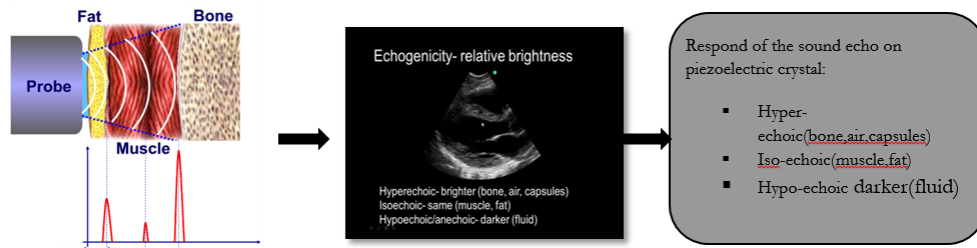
Image generation in ultrasonography
